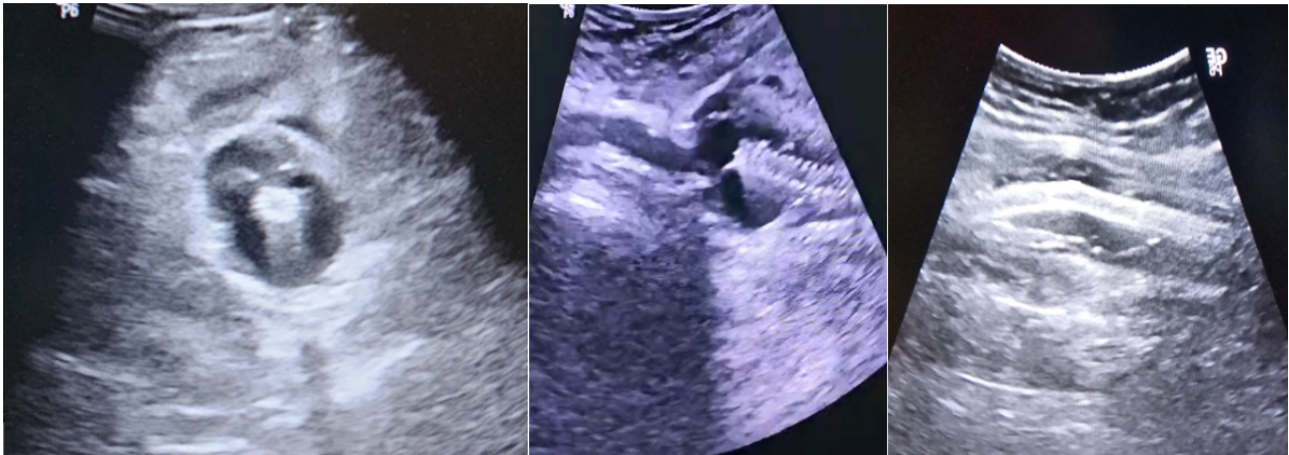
The Doppler ultrasound reveals a distal pseudoaneurysm caused by the rupturing of the distal SFA stent.
